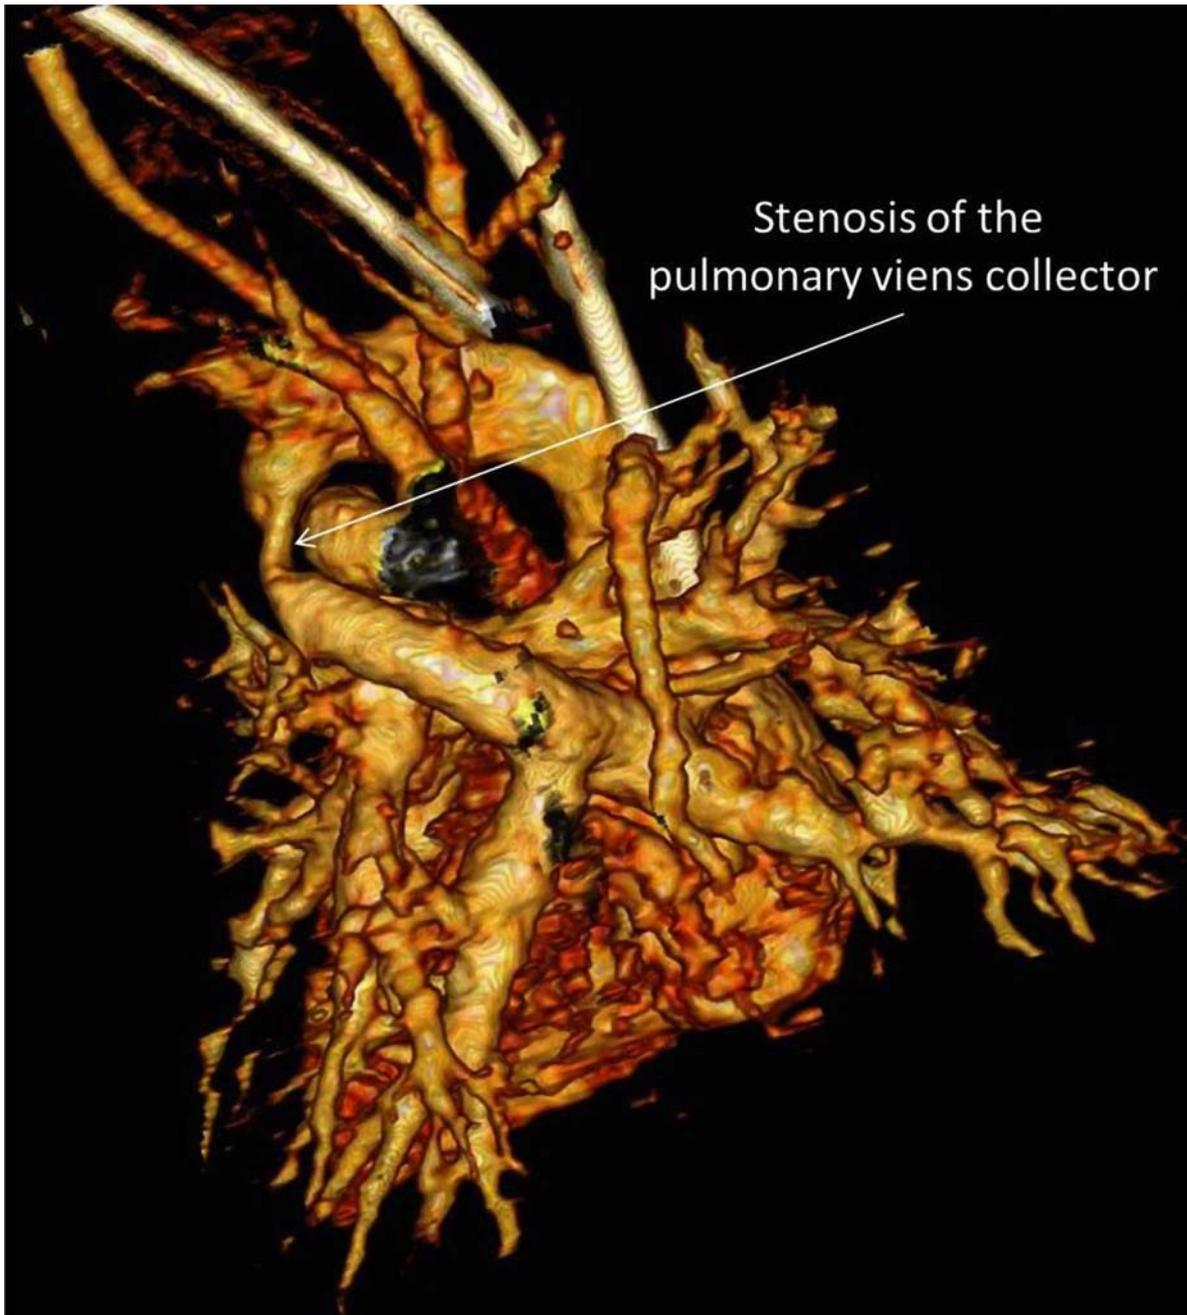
CT scan before surgery. Totally anomalous pulmonary veins connection in to the vertical vein. Collector stenosis marked by the arrow.
